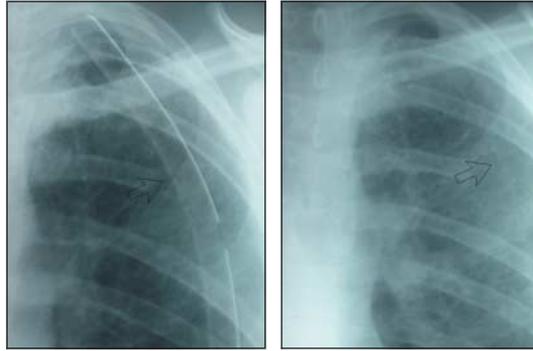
(left) Left apical chest drain (open arrow) in satisfactory position after lobectomy. (right) Chest radiograph after removal of drain next day shows faint radio-opaque line (arrow), known as a “drain track.” This was seen to resolve on subsequent radiographs
